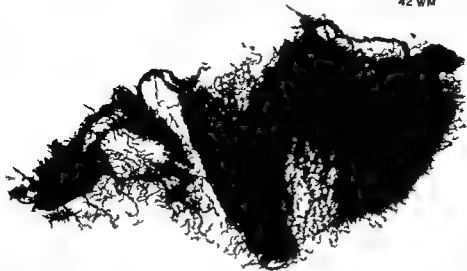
Radiographic view of the coronary artery system of the whole heart which was laid open as described by Fulton to display the vessels
